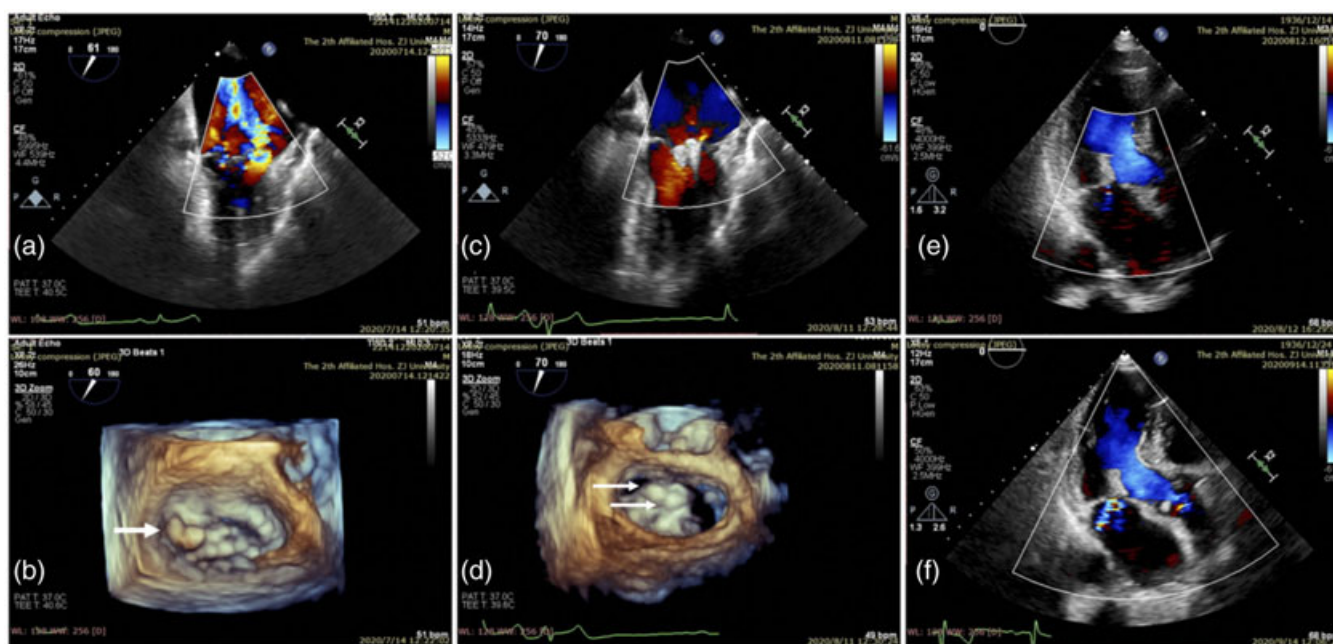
Echocardiogram imaging of this patient. (a) Color Doppler of the mitral valve on transesophageal echocardiography (TEE) prior to implantation. (b) Posterior leaflet prolapse involving the P1 segment (arrow) prior to implantation. (c) Color Doppler of the mitral valve after procedure. (d) 3D TEE view of the mitral valve from the left atrial perspective after procedure; the clips of DragonFly™ located at the prolapsing P1 segment (arrows). (e) Transthoracic echocardiogram at discharge. (f) Transthoracic echocardiogram at 1-month follow-up
